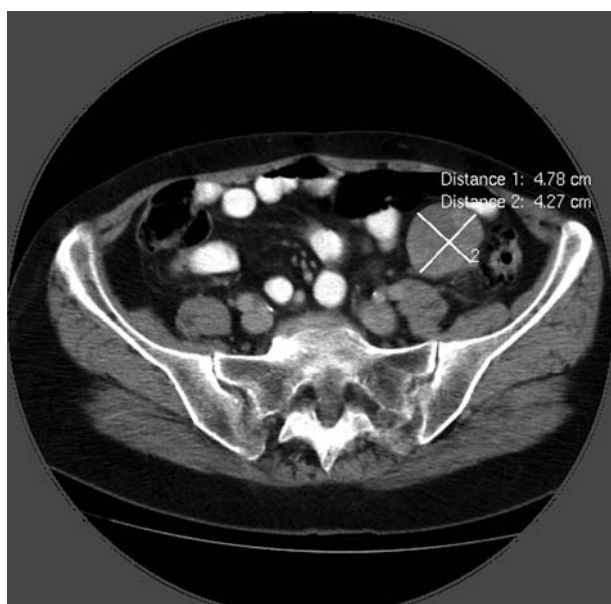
One of the two intraperitoneal metastases detected on a CT scan following adjuvant IM in case 2.
